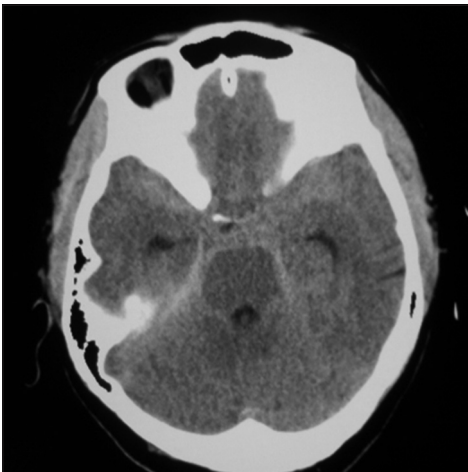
Noncontrast axial computed tomography scan taken at the presentation showing diffuse subarachnoid hemorrhage
